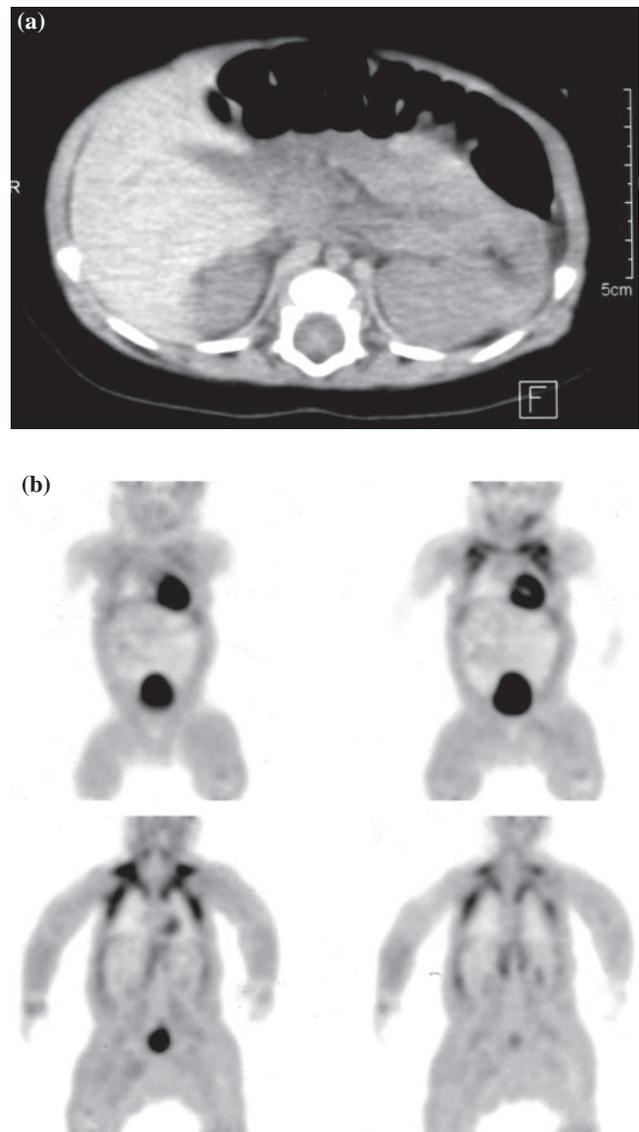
Imaging modalities used to determine the location of focal pancreatic lesion in persistent hyperinsulinaemic hypoglycaemia of infancy. (a) Axial PET-CT scan taken at the level of pancreas. (b) Octreotide isotope scan. No focal lesion can be detected in both scans.
